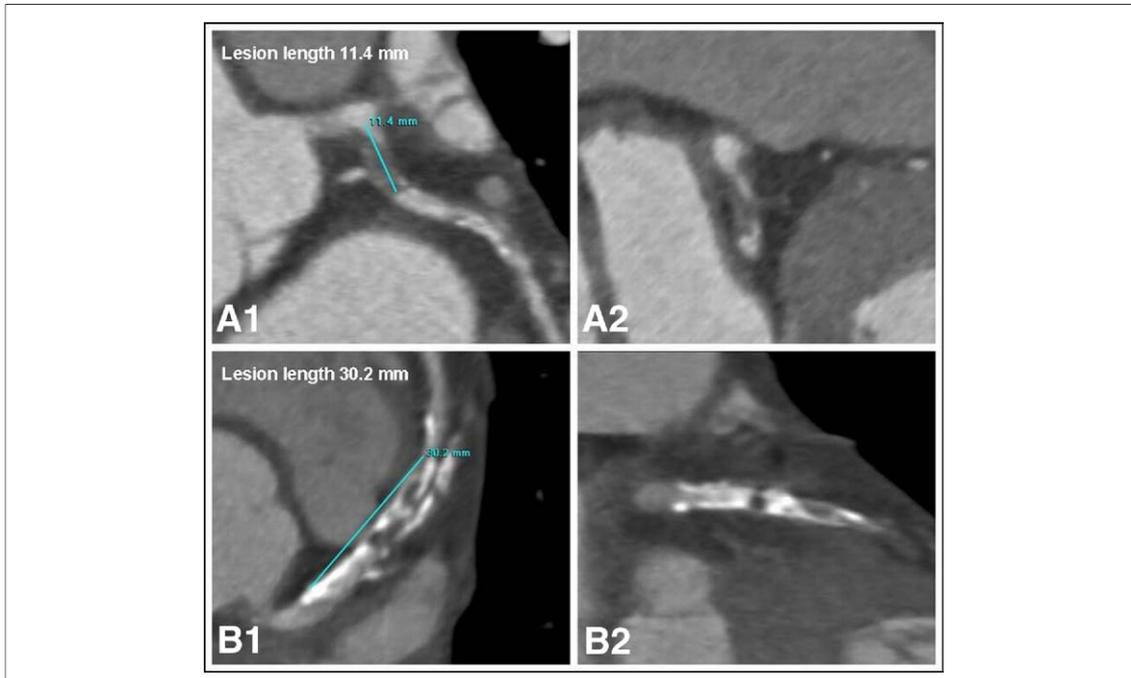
Determining Stenosis Length on CTA
